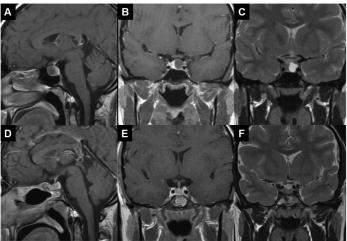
Pre-operative images demonstrating a mesoprolactinoma (15 mm) with optic chiasm compression but no cavernous sinus invasion. Sagittal (A) and coronal T1 weighted MRI with gadolinum (B). Coronal T2-weighted image of the same patient (C). Pos
